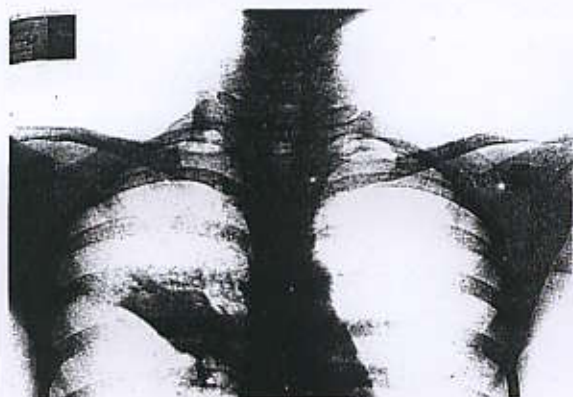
Chest radiograph showed alveolar infiltration at RUL.
